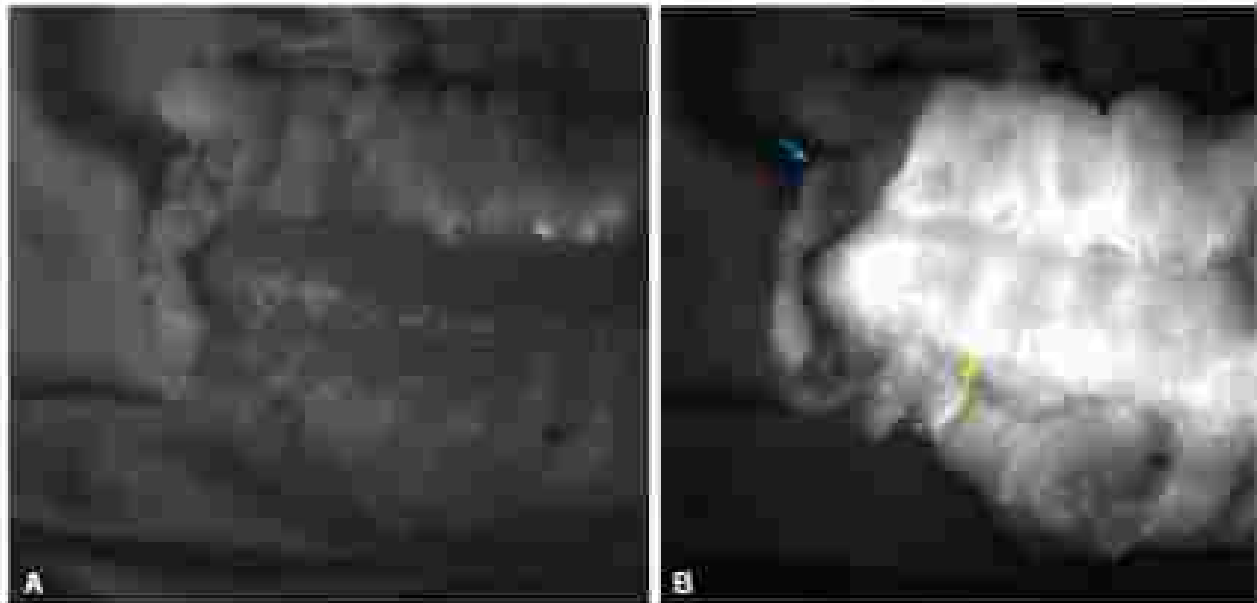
T-intensity phase-contrast CT angiography. (A) Colon before injection. (B) Colon after injection showing ischemia of reaction margin (blue arrow) and normal portions of colon (yellow arrow).
